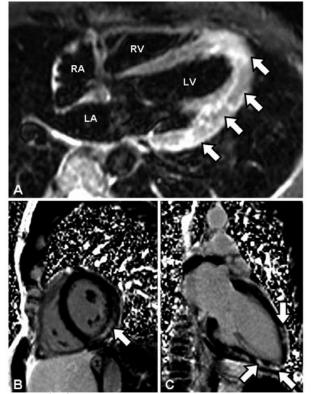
Cardiac magnetic resonance imaging shows normal left ventricular (LV) size and systolic function. Triple short inversion time inversion recovery inversion recovery (STIR) images (precontrast) of the apex and lateral wall demonstrate a patchy high signal consistent with myocardial edema (A). Short-axis (B) and long-axis (C) inversion recovery images obtained 10 minutes after gadolinium infusion demonstrate subepicardial and midmyocardial late gadolinium enhancement involving the LV apex, and the anterior, lateral, and inferior walls, findings consistent with myocarditis. RA indicates right atrium; RV, right ventricle; LA, left atrium.
